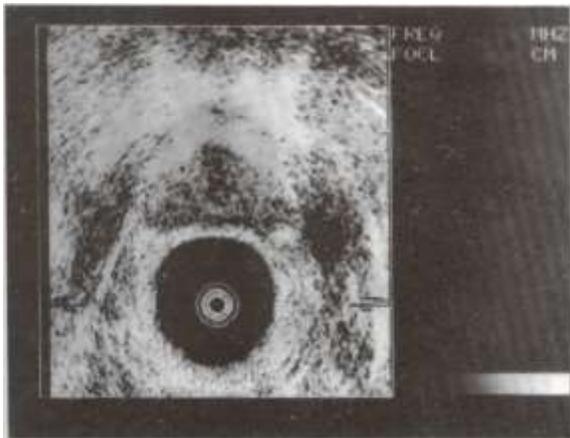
Ultrasound scan of normal prostate.
